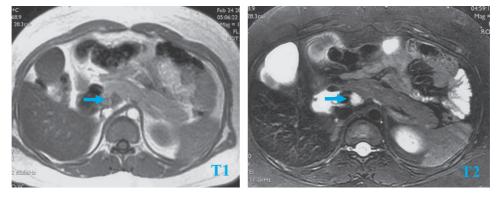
Abdomen Gd enhance MRI (Case 2)
